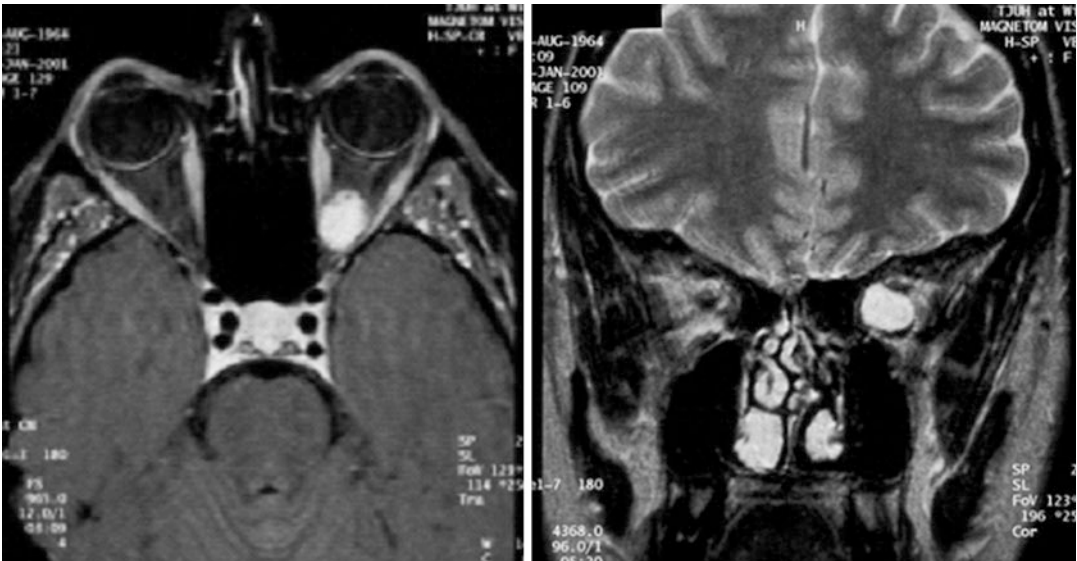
MR imaging, axial (*left*) and coronal (*right*) views, shows a well-circumscribed mass at the left orbital apex
